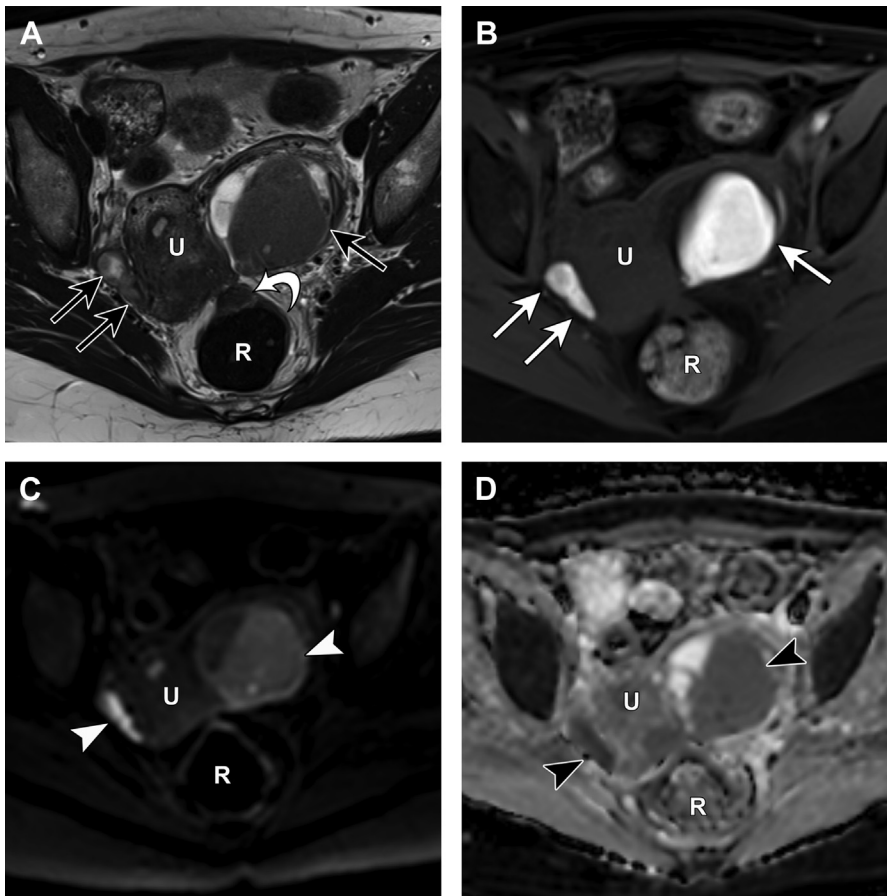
Endometriomas can restrict diffusion due to highly viscous proteinaceous and hemorrhagic contents. Axial T2-weighted image (A) shows T2 shading in endometriomas bilaterally (*black arrows*). A hypointense fibrotic deep infiltrating endometriosis nodule tethers the uterus and anterior rectal wall (*white curved arrow*). Axial T1-weighted MR image with fat saturation (B) shows marked hyperintense homogenous signal within multiple endometriomas bilaterally (*white arrows*). Axial diffusion-weighted MR image (b-value = 800) (C) with intermediate to high signal within the endometriomas (*white arrowheads*). (D) Axial apparent diffusion coefficient map shows low signal within the endometriomas, confirming diffusion restriction (*black arrowheads*). U, uterus; R, rectum.
